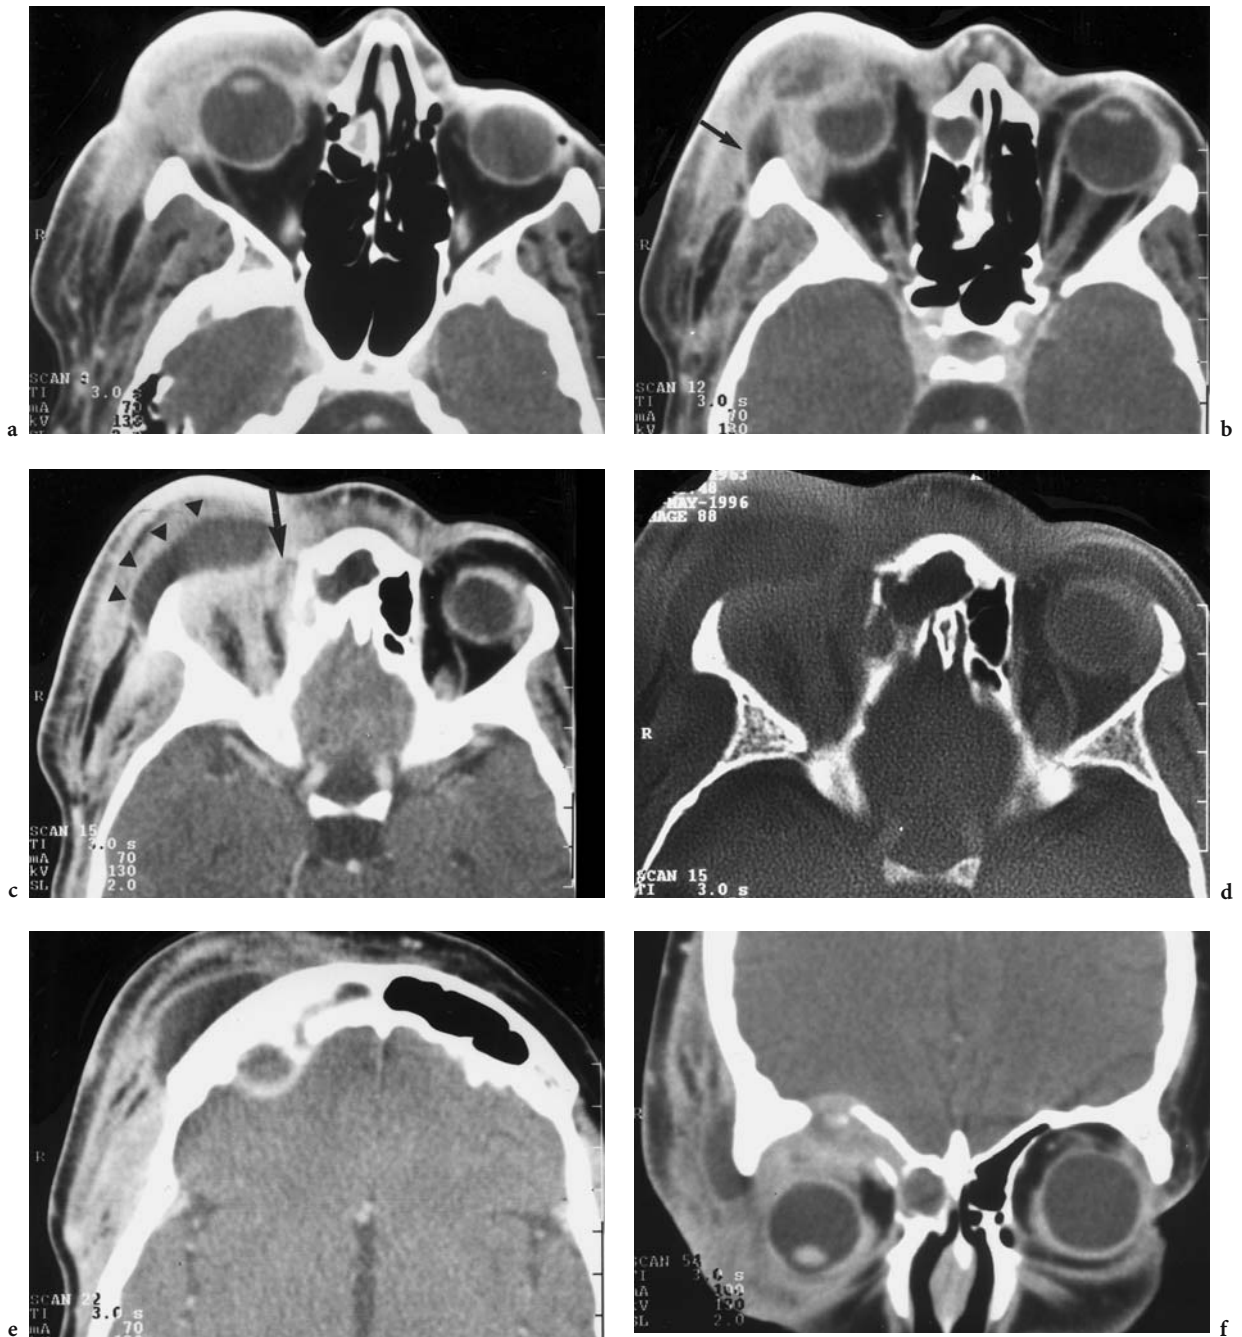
A 21-year-old woman with headache persisting for 2 weeks and swelling of right cheek and face, including the right eye; a physician was consulted for her continuous febrile state. Diagnosis: phlegmon of the right face with intracranial extension, caused by ethmoidal pyoceles. CT: a Axial contrast-enhanced image of the inferior orbit with inferior globe dislocation and preseptal inflammation, expanding subcutaneously to the temporal fossa. Note that the paranasal sinuses are normal despite the presence of a small, ipsilateral, paramedial ethmoidal cell. b Axial contrast-enhanced view at the level of the optic nerve showing infiltration of the lacrimal gland, as well as a small subcutaneous necrotic area rostral to the zygomatic process (*small arrow*). Note widening of the paramedial ethmoidal cell with apparent necrotic content and destruction of the corresponding lamina papyracea. c Axial contrast-enhanced view at the level of the superior ophthalmic vein, identifying the largest necrotic area (*triangles*). Slight postseptal infiltration of the medial orbit is detectable in the region of the superior ethmoidal cells (*arrow*) and is characterized by an irregular formation. d Corresponding bone window demonstrating erosion and destruction of the ethmoidal cell septa, the apparent origin of the inflammatory process. e Axial contrast-enhanced view at the level of the frontal brain parenchyma reveals necrotic subgaleal swelling, intracranial, extradural inflammatory infiltration and inflammatory destruction of the frontal posterior sinus wall. f Coronal view demonstrating the pathological changes consisting of ethmoidal pyocoeles as the apparent origin, the extent of the inferior and rostral globe dislocation, the extent of the soft-tissue infiltration, the destruction of the frontal base, and the intracranial extradural extension
